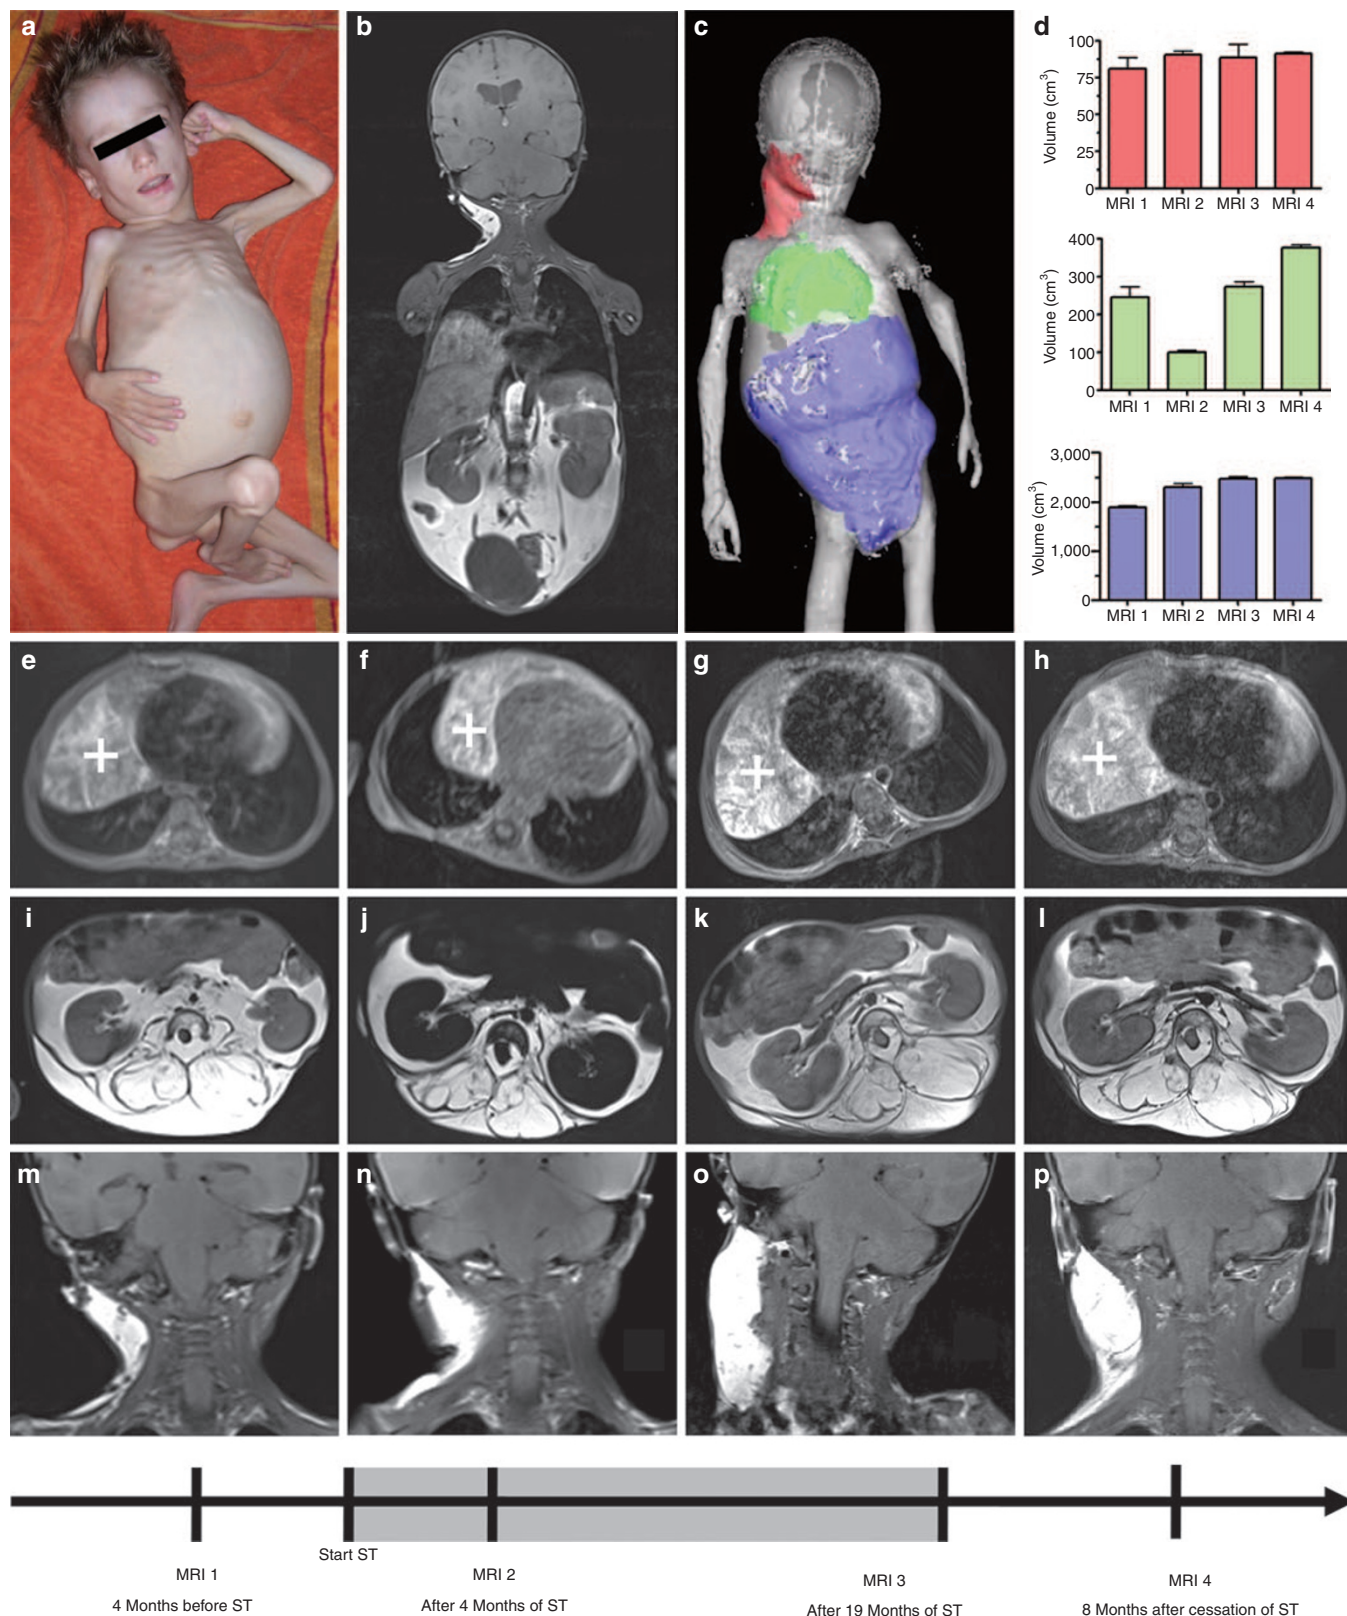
Clinical presentation of a boy with phosphatase and tensin homolog hamartoma tumor syndrome (PHTS). (a) The photograph shows the patient at the age of 3 years with cachexia and the protruded abdomen. (b) Retroperitoneal fat masses are apparent in the magnetic resonance imaging (MRI). (c) Regions of interest of the lipoma at the neck (red), the hyperplastic thymus (green), and the abdominal lipomatosis (blue) were marked in a three-dimensional reconstruction of an MRI and (d) quantified as shown in the graphs to monitor tumor growth. (e–h) The enlarged thymus (marked with a white plus) shrank during the first 4 mo of sirolimus treatment (ST) and increased in size after 19 mo and further after cessation of therapy. (i–l) The abdominal lipomatosis did not decrease in size until the 19th mo of sirolimus therapy. (m–p) The solitary lipomas, e.g., at the right neck, did not change in volume. The shaded area on the time line indicates the duration of sirolimus treatment. Parental consent to publish this photograph was obtained by the authors.
